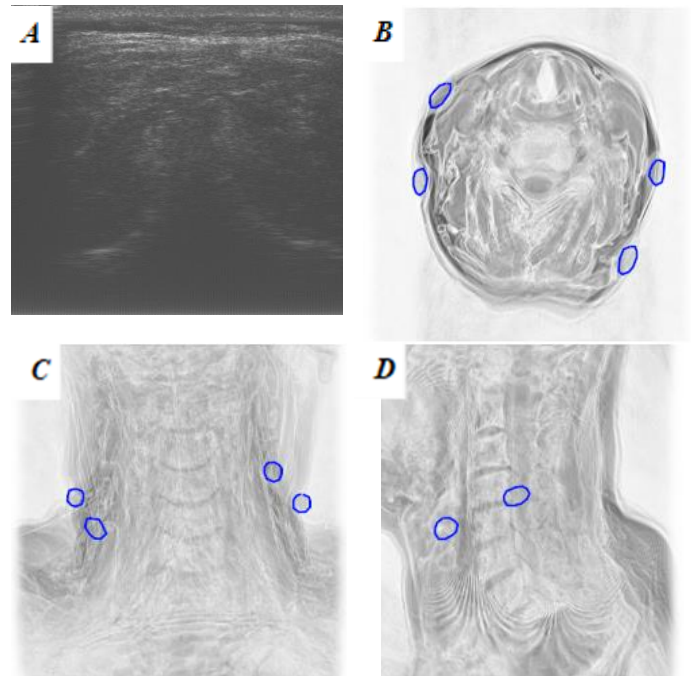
Linked US-MRI dataset
